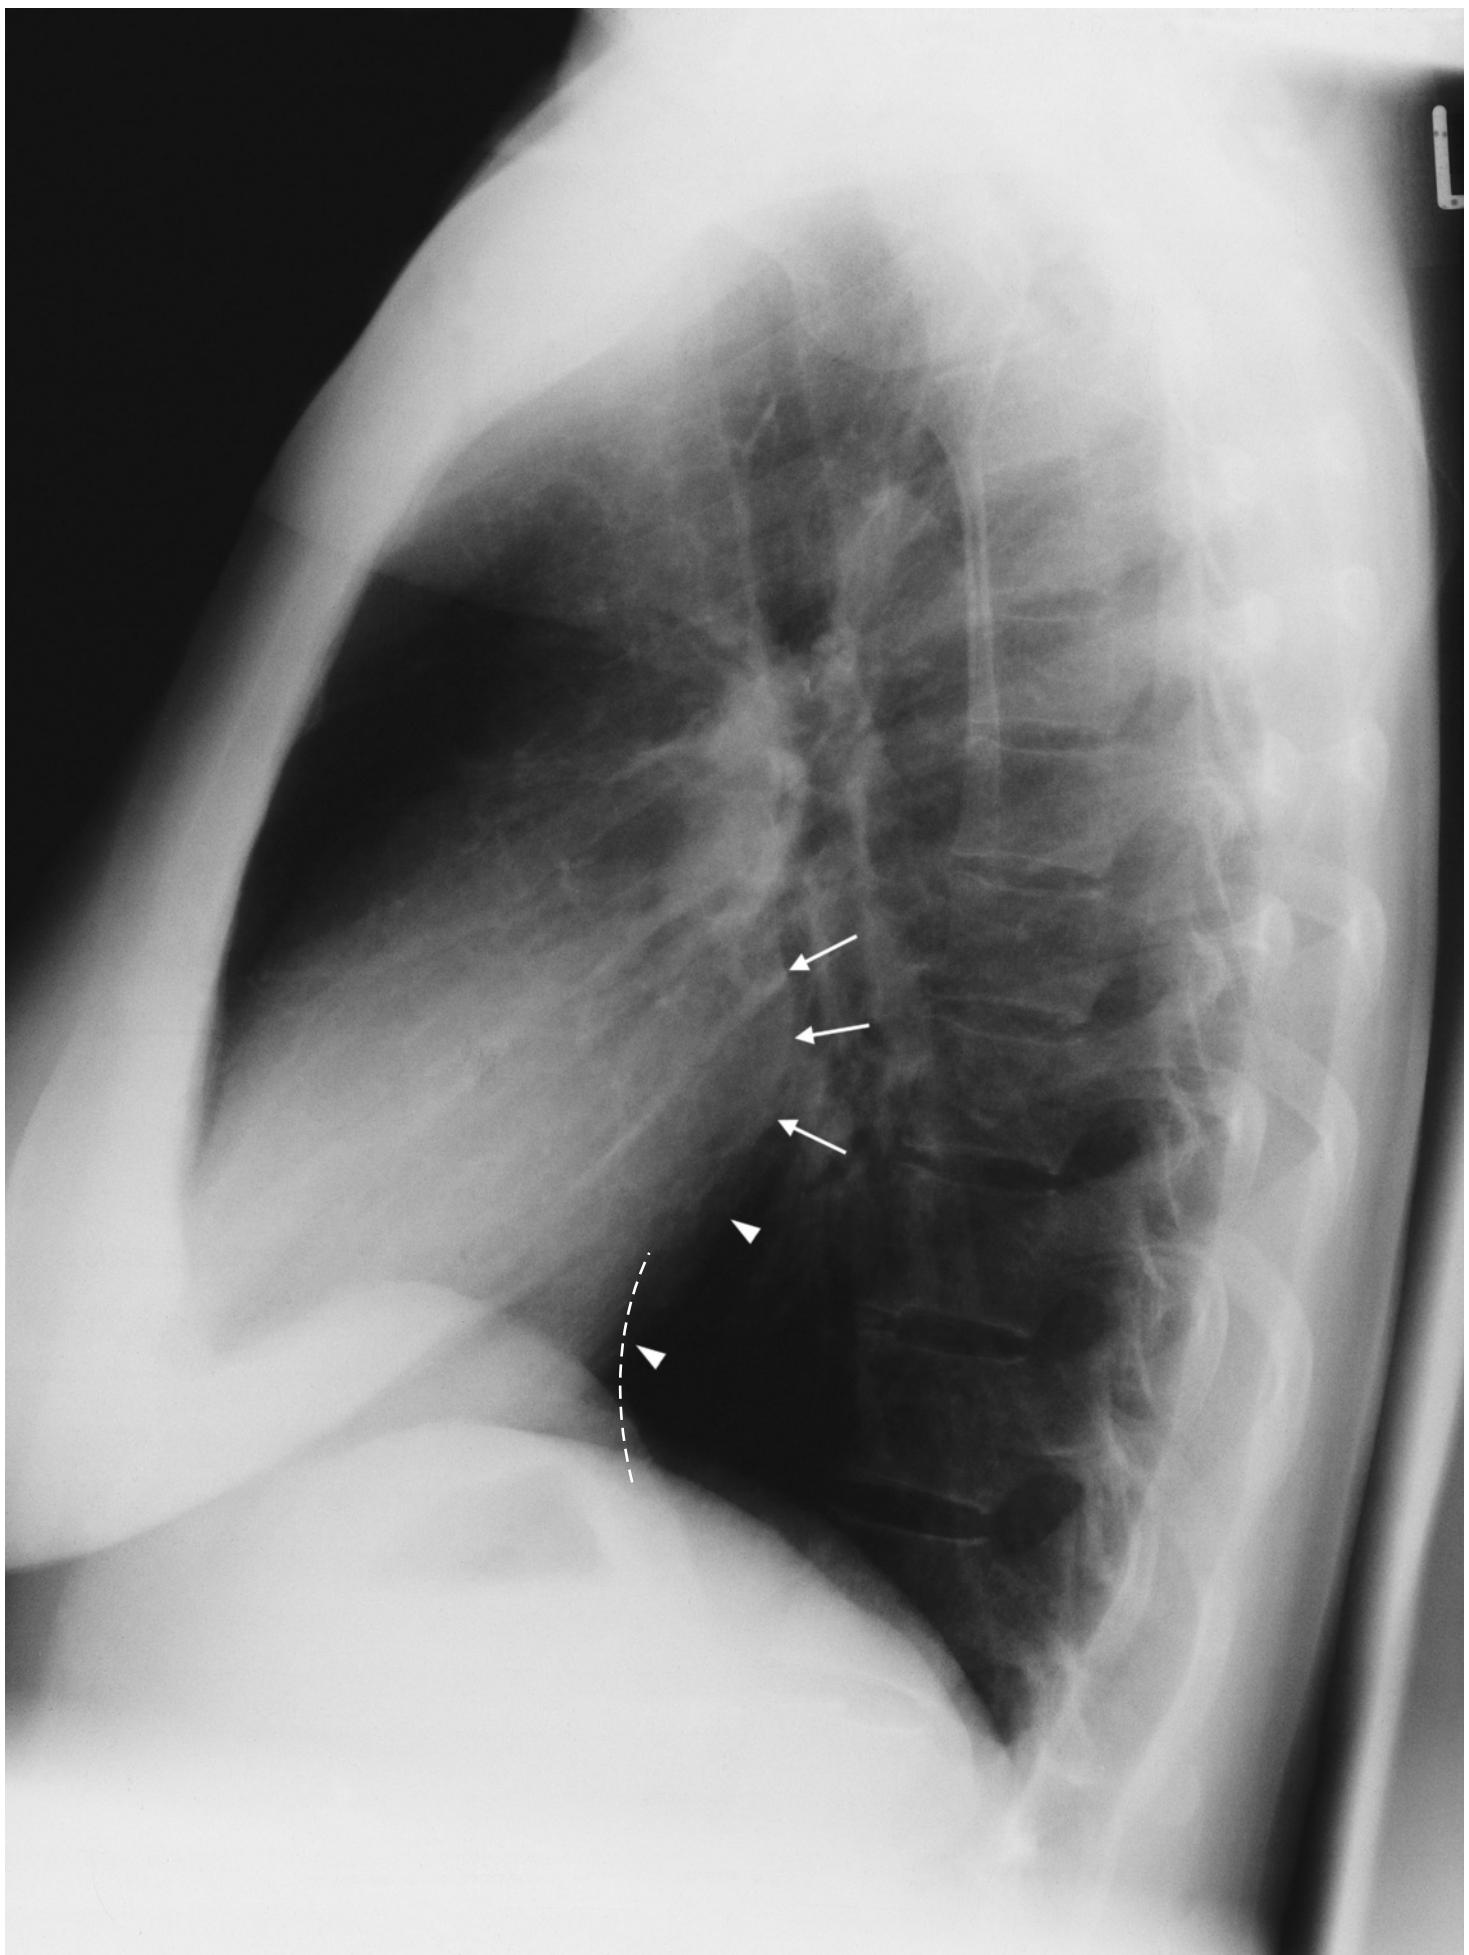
Lateral chest radiograph of a 44-year-old woman obtained in tumor staging (normal findings). The posterior border of the heart shadow is formed by the left atrium (white arrows) and ventricle (white arrowheads).
